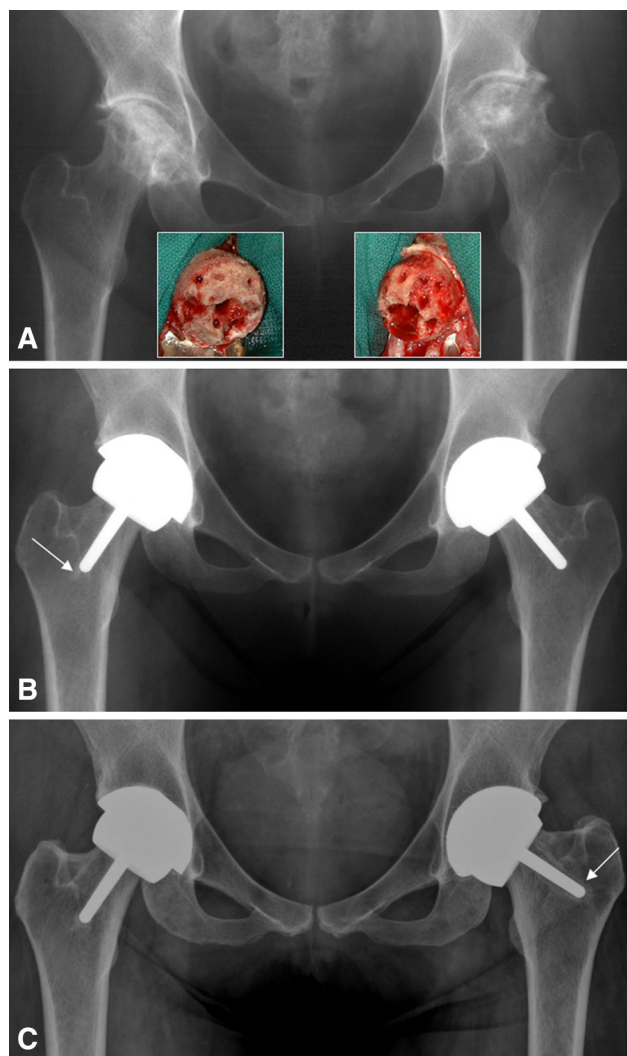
The AP radiographs of the hips of a 31-year-old female with bilateral osteonecrosis secondary to systemic lupus erythematosus are shown. Surgery was performed on both hips in one stage. (A) A preoperative radiograph has insets of intraoperative photographs of the femoral heads after bone preparation. The patient's surgery was performed before increased irrigation and suction techniques were implemented. The bone quality was visibly poor in both heads with slightly larger defects on the right. (B) No evidence of femoral radiolucency was seen on the immediate postoperative radiograph, with the stem cemented on the right (arrow). (C) Four years after surgery, a large radiolucency around the uncemented stem on the left can be seen, with a sclerotic halo of bone surrounding the stem tip. The component also has tipped into a more varus distal position. Fourteen years after surgery, the patient has begun to experience pain associated with weightbearing activities and is pending revision surgery. Her current UCLA scores for pain are six for the left hip, 10 for the right hip, and her walking, function, and activity scores are 8, 8, and 4, respectively. (Reprinted from Amstutz HC, Le Duff MJ, Campbell PA, Dorey FJ. The effects of technique changes on aseptic loosening of the femoral component in hip resurfacing: results of 600 Conserve[®] Plus with a 3–9 year follow-up. *J Arthroplasty*. 2007;22:481–489.)
